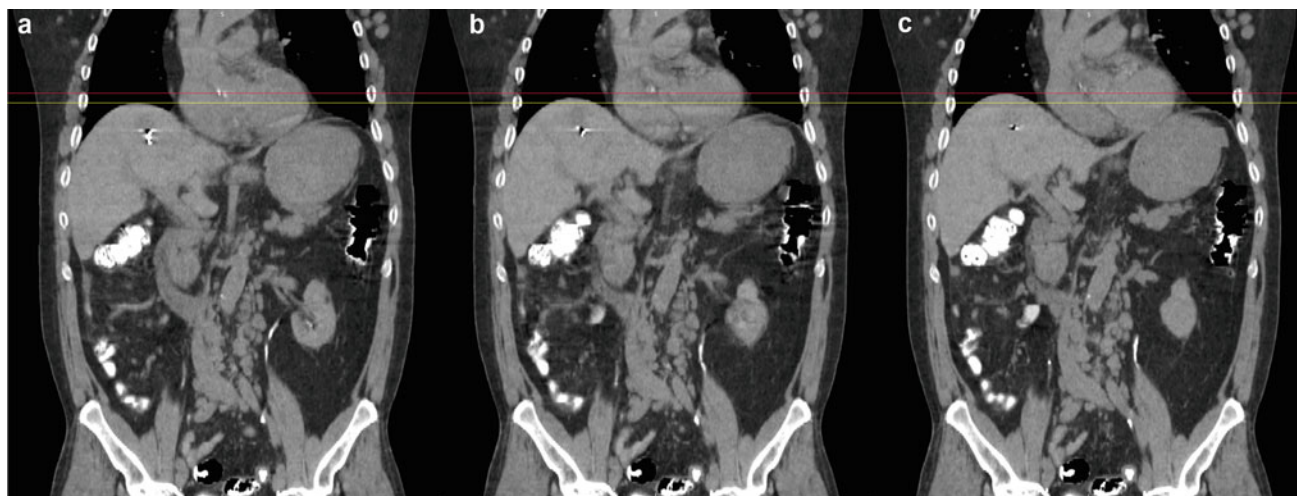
Coronal CT demonstrating tumor motion throughout the respiratory cycle in the same patient. a End inspiration b mid-cycle and c end-expiratory. *Red and yellow lines* represent same plane at
